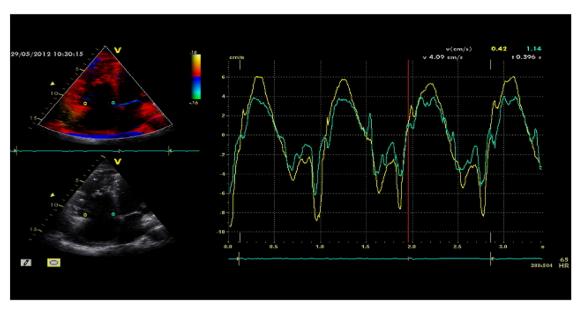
Colour Tissue Doppler Imaging for assessment of RV function at septal & lateral Tricuspid annulus from the apical 4Ch view (patient No 16).
